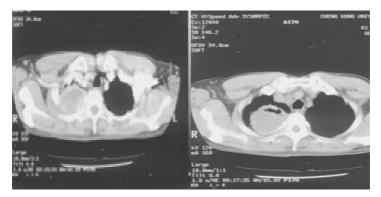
Pre-treatment chest CT: SqCC of RUL with central necrosis
